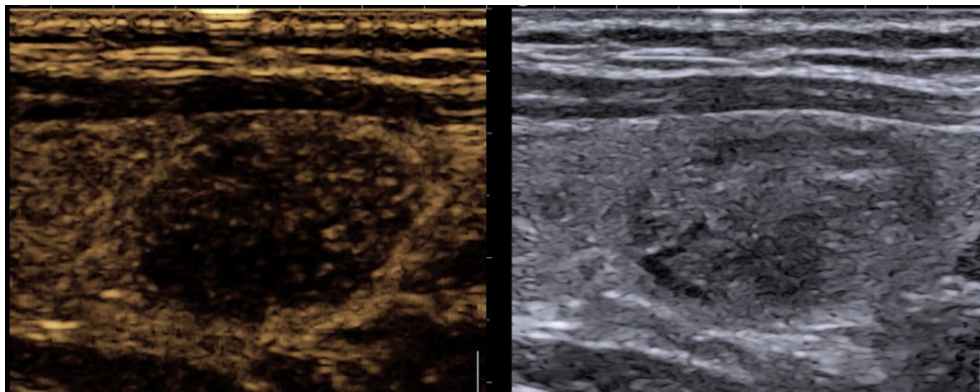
Contrast-Enhanced Ultrasound (CEUS) for thyroid cancer. A solid, well-defined, isoechoic with some areas of hypoechogenicity which includes the nodule in EU TIRADS 4, CEUS high risk due to diffuse hypoechancement (upgraded to modified-TIRADS 5) = medullary thyroid cancer. TIRADS 4 represents nodules with moderate suspicion of malignancy, whereas TIRADS 5 includes those with high suspicion, often requiring biopsy confirmation.
